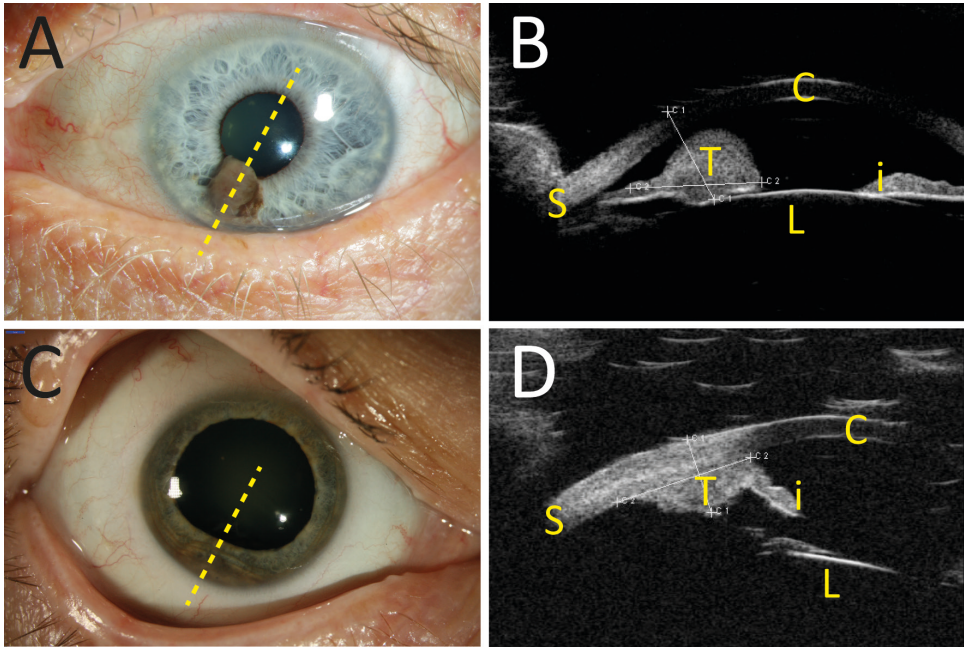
Clinical presentation of iris melanoma and ciliary body melanoma. (A) Pigmented lesion of the iris. The dotted line indicates the cross section as presented by ultrasonography in panel B. (B) Ultrasound image of the same patient as in A. note the nodular configuration, limited to iris tissue. (C) Pigmented lesion of the ciliary body, inferior. The dotted line indicates the cross section as presented by ultrasonography in panel D. (D) Ultrasound image of the same patient as in B. Note that the lesion originates from ciliary body tissue, and is located behind the iris.
